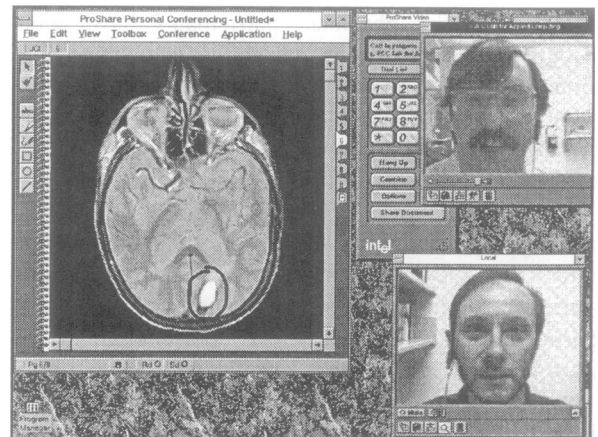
PC video conference, showing the "whiteboard" and an MRI image with a circled tumor.
